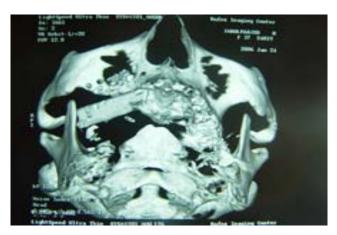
Another view of the transferred flap (3D CT-scan).
